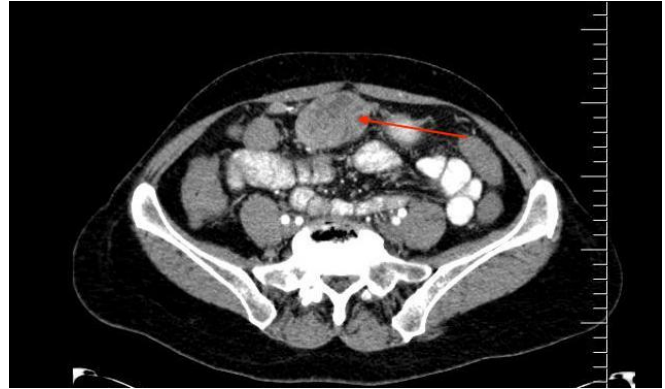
B: Sagittal Computed tomography image of the mass (Red arrow).
